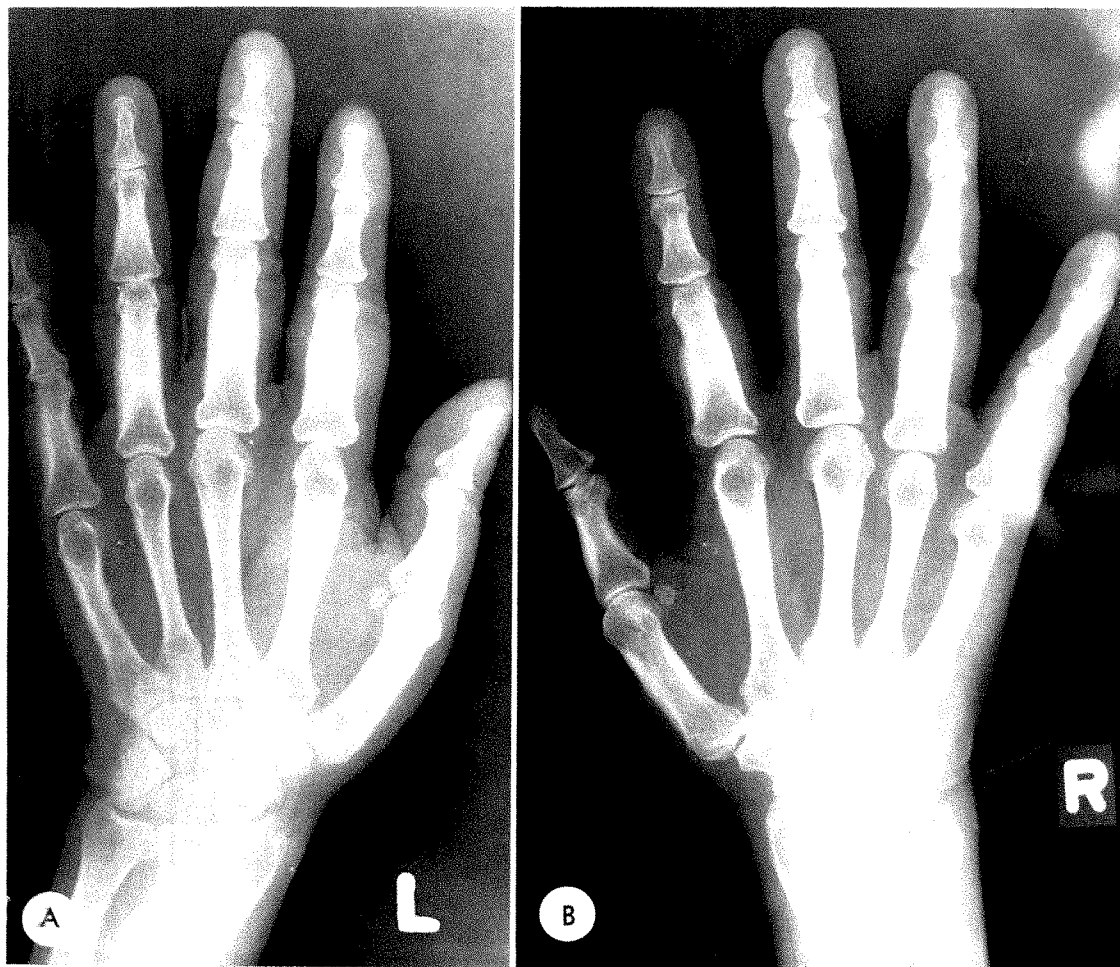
(*A* and *B*) Roentgenograms of the hands showing diffuse, symmetric, periosteal new bone formation about the shafts of the proximal phalanges and both first metacarpals. Compare *A* with Figure 5.
